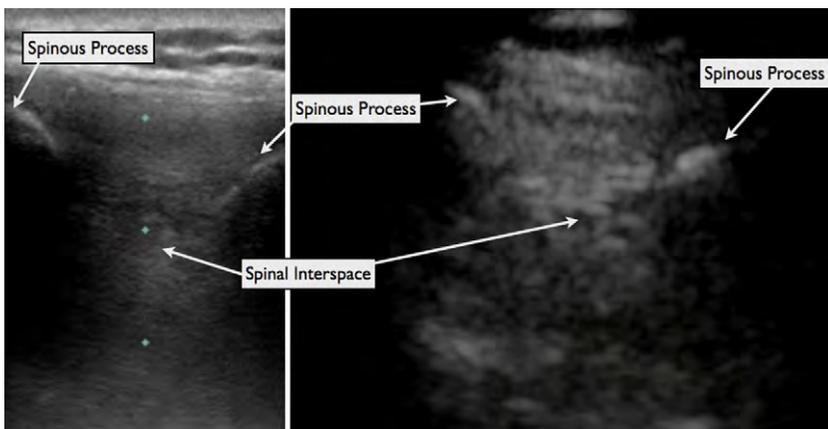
The spinal interspace on ultrasound imaging in the longitudinal view. The left image is with use of a high-frequency probe, and the right image is with use of a low-frequency probe.
